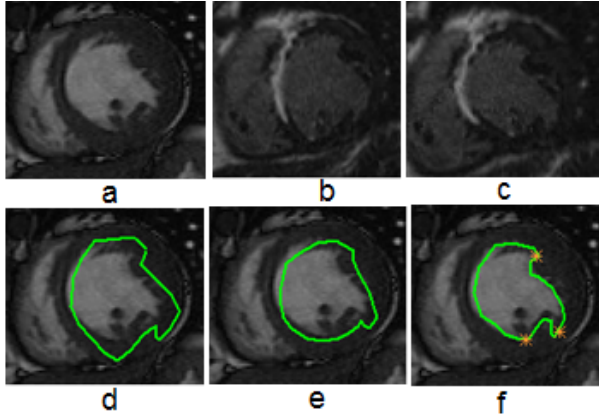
Comparison between intensity-based method and the hybrid method. a: cine image. b: DE-MRI. c: aligned DE-MRI by CCPD. d: before registration. e: CC registration. f: CCPD registration.
